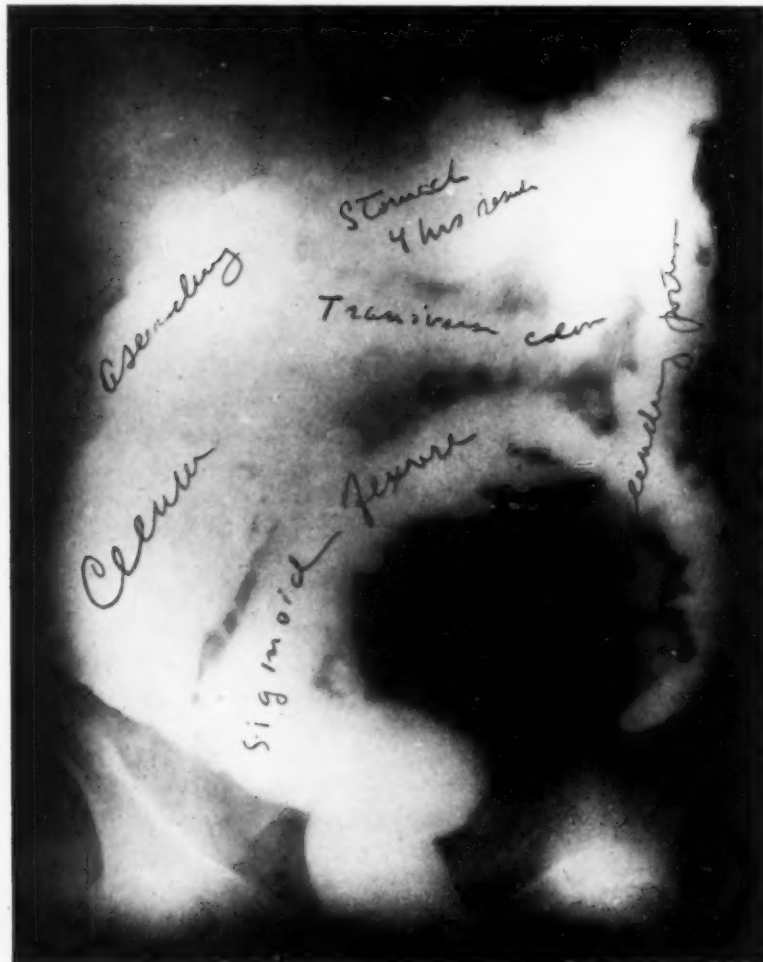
Conditions revealed by X-ray in case reported.
